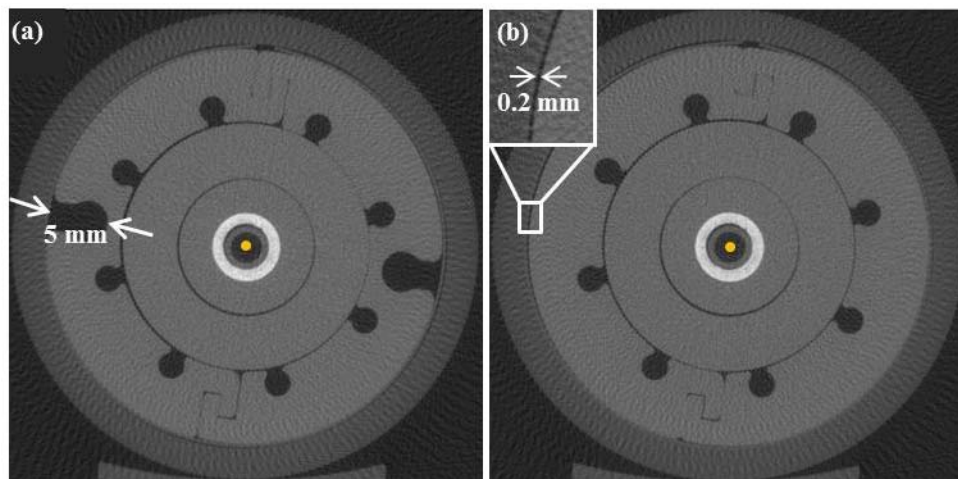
μ CT cross-sectional slices of the MCVC applicator with the vaginal tube, and film wrapped around the applicator and held in place with the acrylic sleeve. The central yellow dot is scaled to represent the microSelectron-HDR® Ir-192 v2 source with a 0.9 mm diameter. The images reveal a groove depth of 5 mm (a), and a maximum air gap between the applicator and the film of 0.2 mm (inset b).
